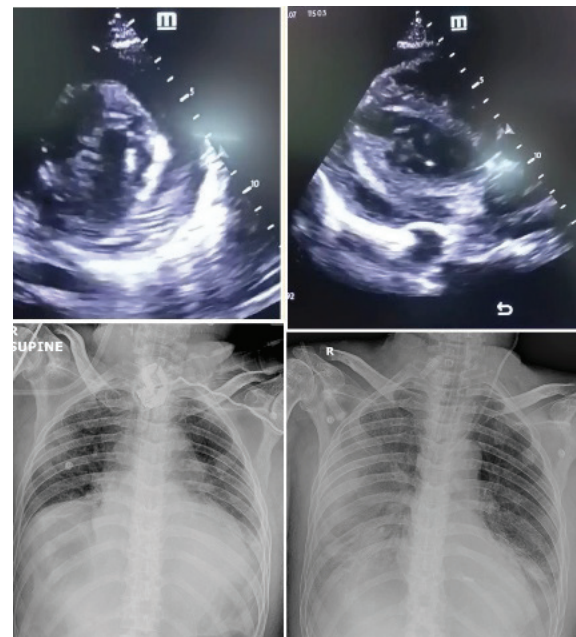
Initial Bed Side Point of Care Echocardiogram (Figure 2 A) & Post ICU admission Chest X rays (Figure 2B) (Initial one (Right) & Latest one before death (Left)).
